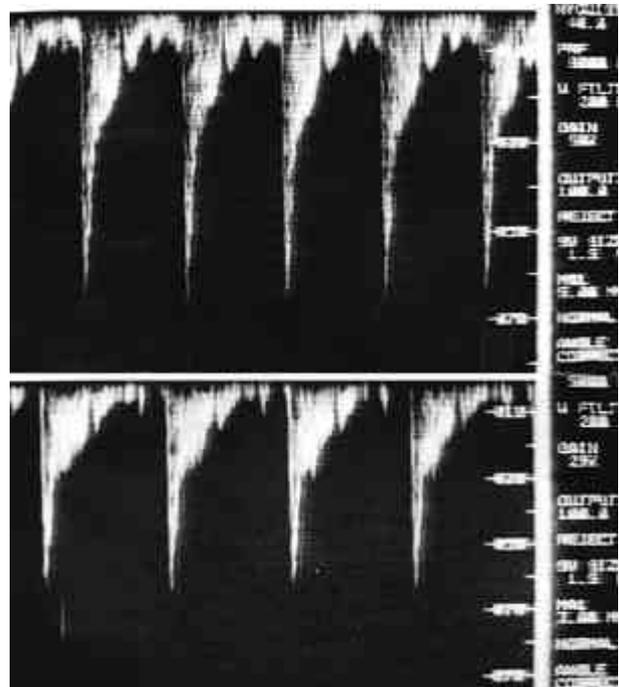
Doppler waveforms of the branch pulmonary artery. Upper panel shows continuous diastolic flow till the next systole. Lower panel shows diastolic flow returns to baseline before the next systole begins.
